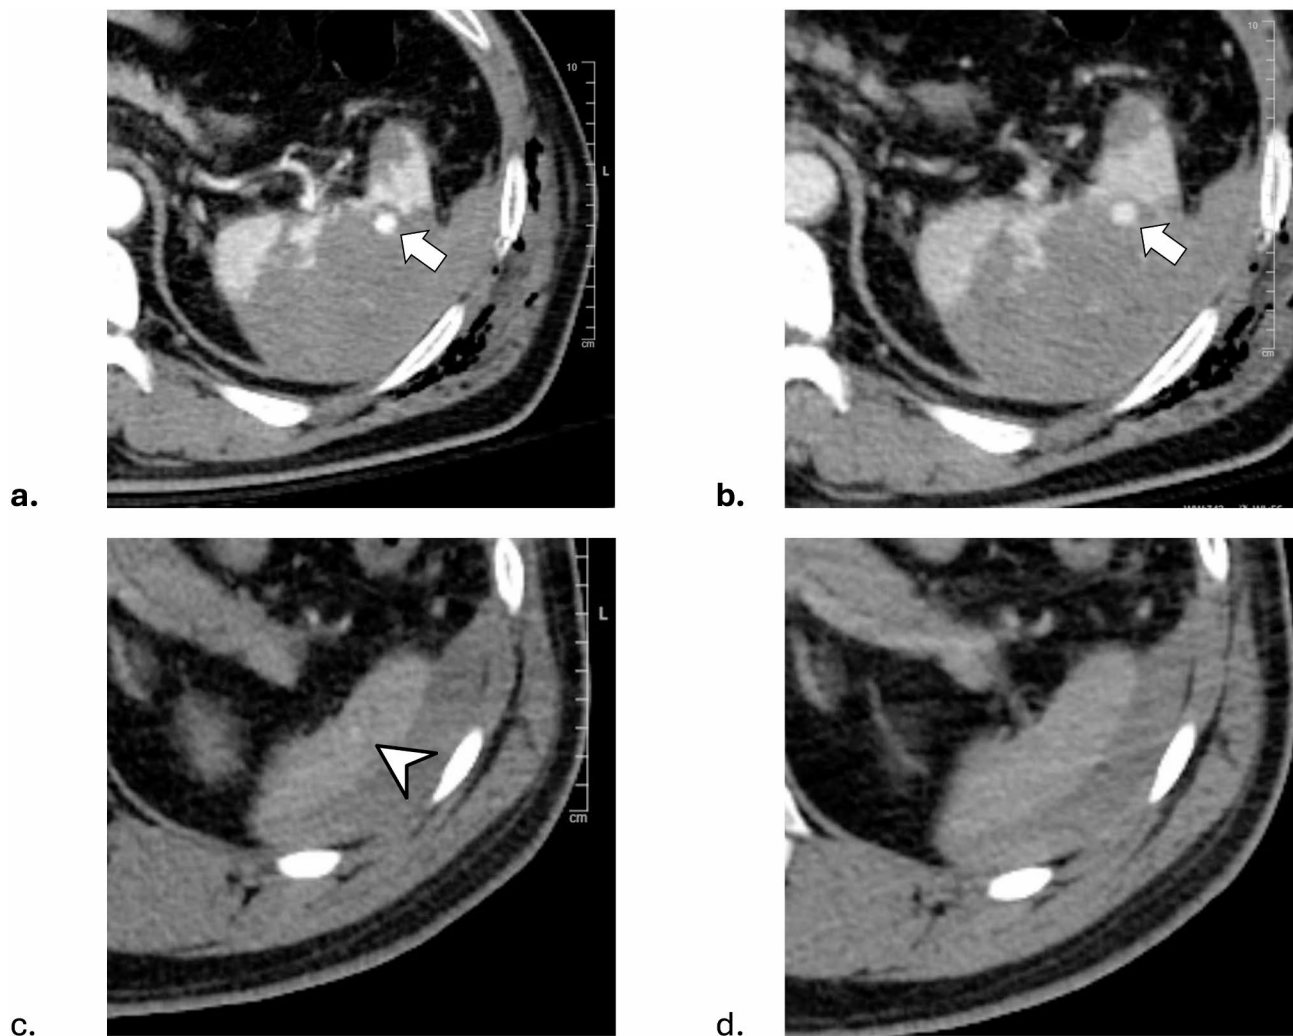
Pseudoaneurysm appearance across different phases. A large splenic pseudoaneurysm (arrow) is visible in both (a) arterial-phase contrast-enhanced CT and (b) venous-phase CT, characterized by a high-density contrast collection. Only one patient in this cohort had a vascular lesion, a small pseudoaneurysm (0.7 cm) (arrowhead), which was exclusively detected in the arterial phase (c) but not visible in the venous phase (d)
